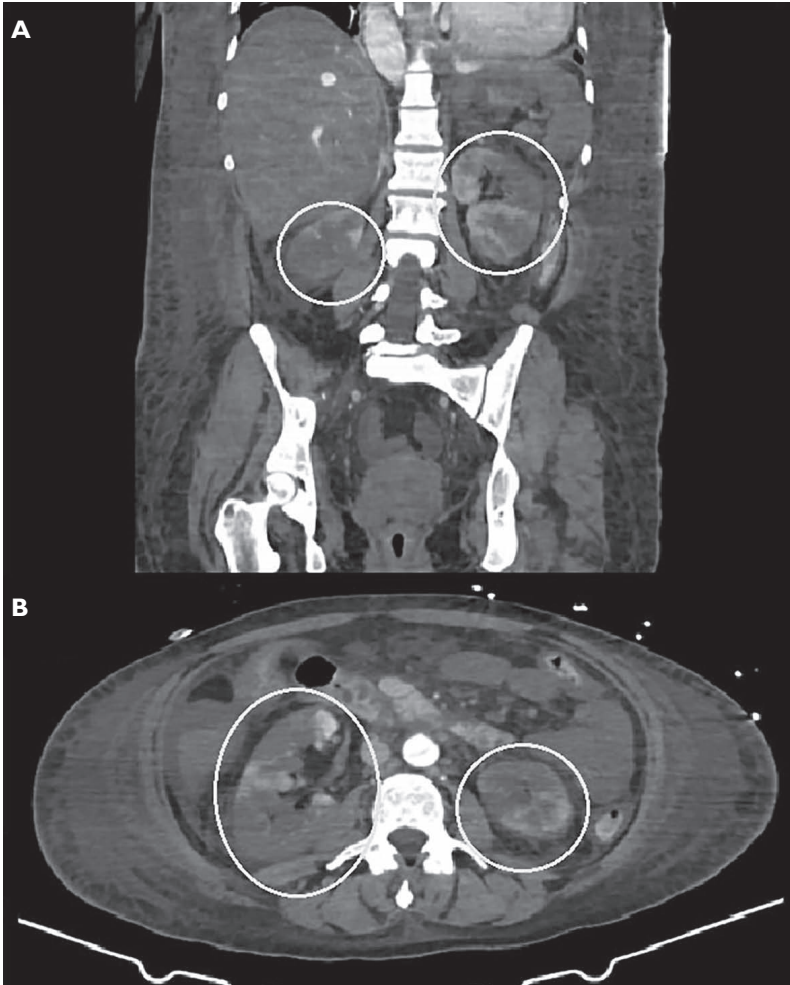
Computed tomography angiography scans in coronal (A) and axial (B) planes, showed a severe condition of hypotension, with the contrast medium in the aortic vascular lumen even in delayed scans and abdominal visceral mal perfusion, especially liver and kidneys (circled the kidneys, in an end-stage condition due to hypotension), associated with a massive free abdominal fluid and oedema of soft tissues.
